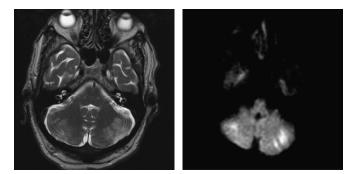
Bilateral cerebellar stroke in a 79-year-old man with biopsy-proven GCA (T2- and diffusion-weighted MRI sequences).
